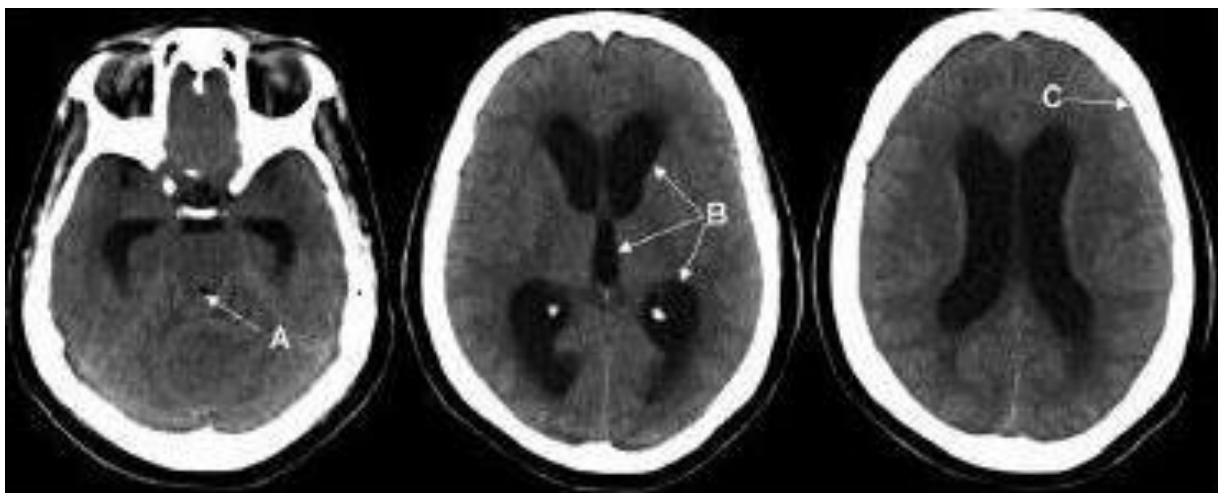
CT SCAN OF A PATIENT WITH HYDROCEPHALUS.
